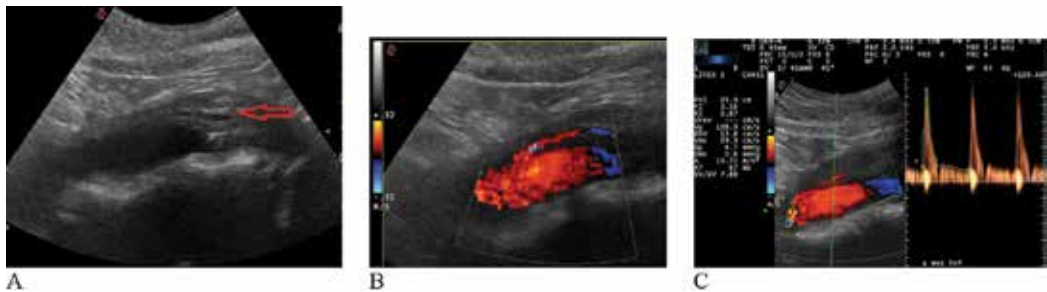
Abdominal ultrasound in a patient with idiopathic RPF (arrow) with involvement of the abdominal aorta and inferior mesenteric artery (A and B), no Doppler data for stenosis of the inferior mesenteric artery (C). *Courtesy of Dr. R. Krasteva-Lolova.*
